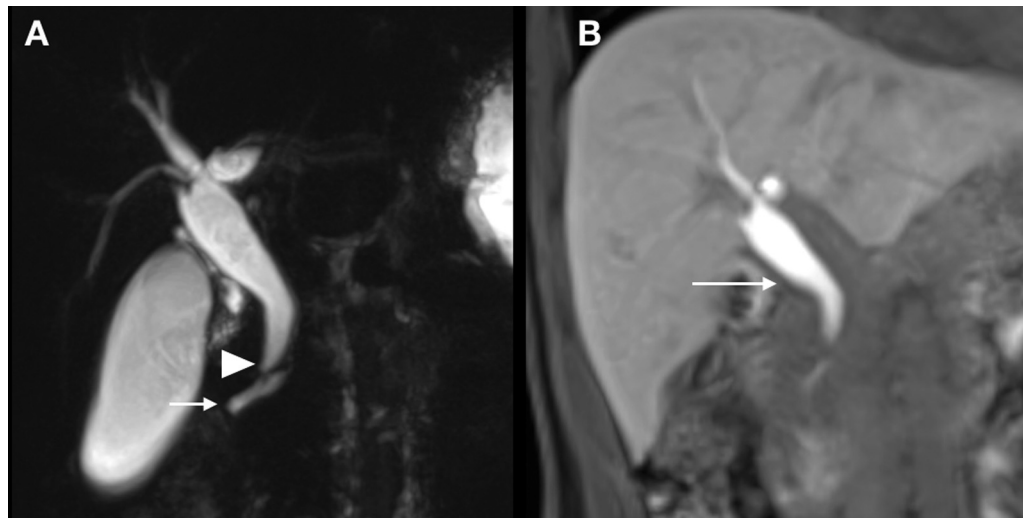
Young child presented with abdominal pain. Ultrasonography (USG) showed dilatation of common bile duct (CBD). Magnetic resonance cholangiopancreatography (MRCP) was performed for further evaluation. Coronal MRCP images (A) showing fusiform dilatation of the CBD suggestive of choledochal cyst with narrowing at lower end (arrowhead) and pancreaticobiliary maljunction with long common channel (arrow). (B) Excretion of hepatobiliary contrast into the choledochal cyst (arrow).
